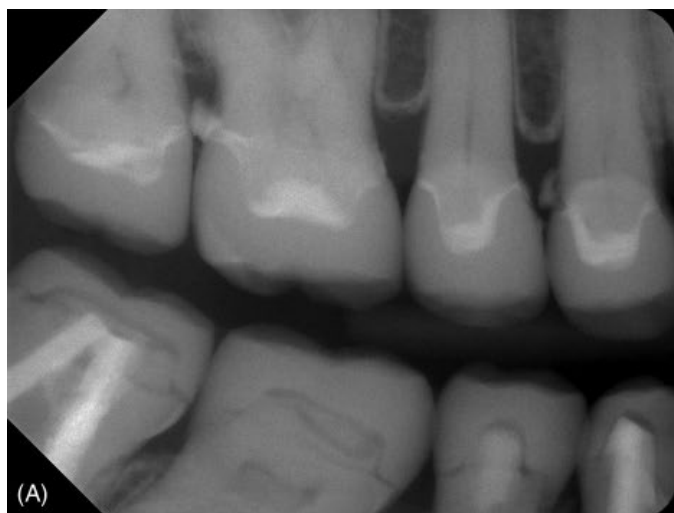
(A, B) Digital radiographs are a safe and effective way to determine if residual cement remains following the cementation of a restoration.
